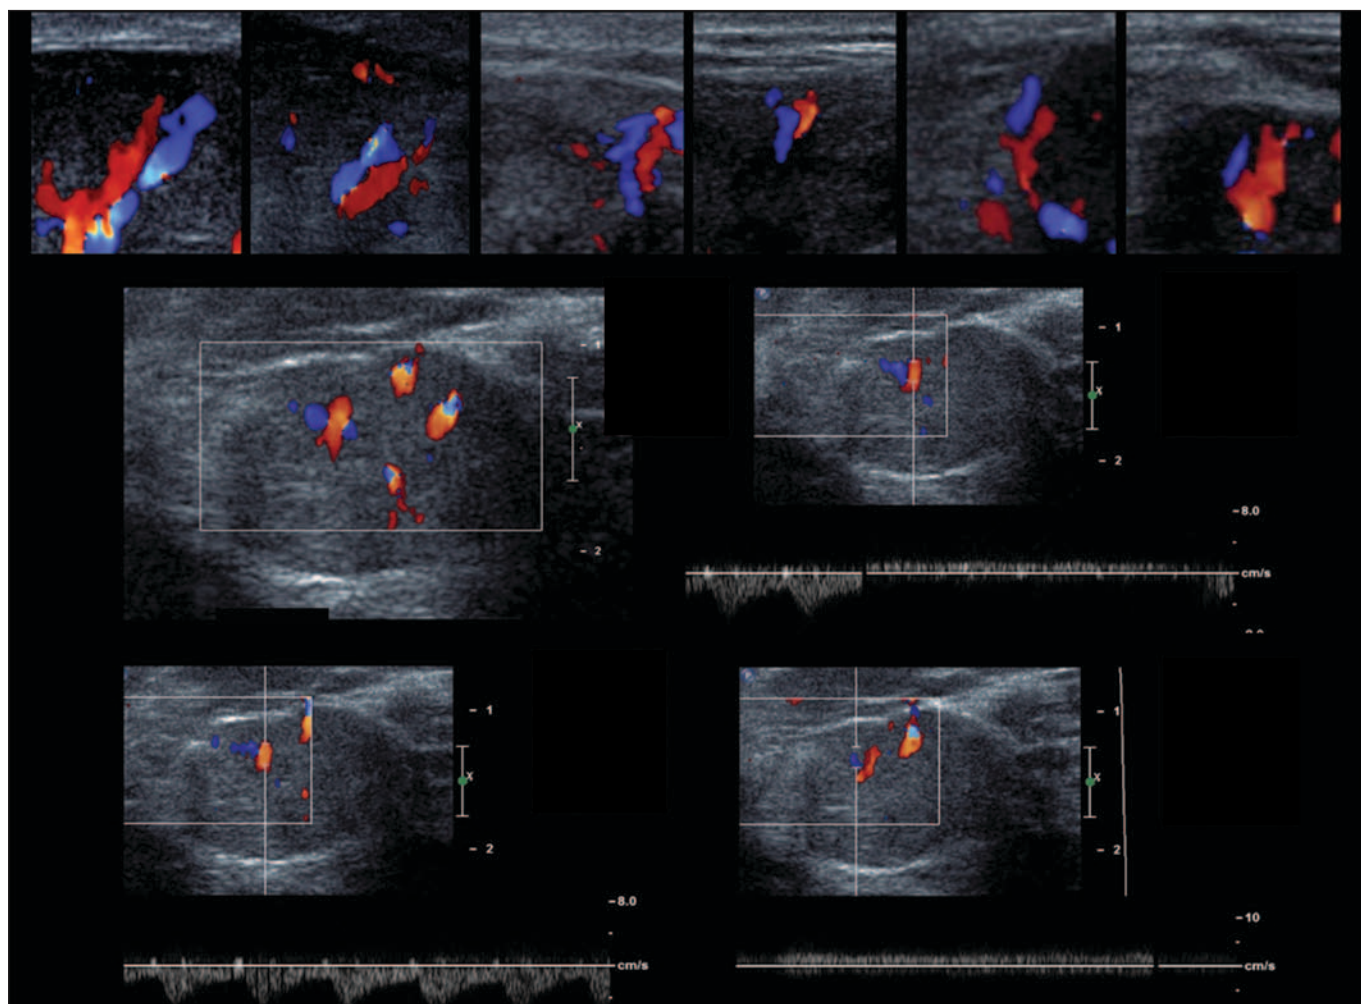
38-year-old woman with breast mass. Ultrasound images (top row) show parallel blood flow in periphery and interior of breast mass corresponding to artery (red) and vein (blue) and signifying normal anatomic condition. Parallel artery and vein sign is present. Pulsed Doppler ultrasound images confirm venous and arterial characteristics of fluid.
